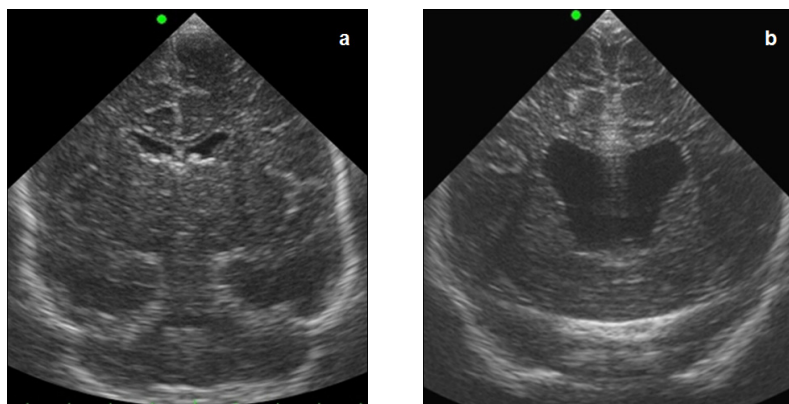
Coronal cUS (a) of preterm infant (gestational age 25.0 weeks), scanned at postmenstrual age 42.0 weeks, showing mild dilatation of lateral ventricles (MRI-cUS white matter score: normal/mildly abnormal), and coronal cUS (b) of another infant (gestational age 30.3 weeks), scanned at postmenstrual age 41.9 weeks, showing severe lateral ventricular dilatation (MRI-cUS white matter score: severely abnormal).
